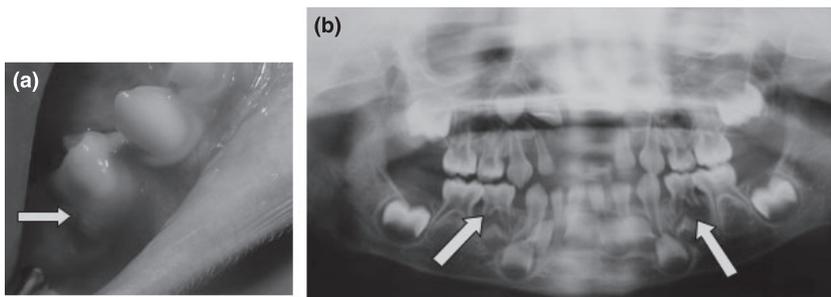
Clinical view (a) and orthopantomogram radiograph (b) from patient 1. (a) The white arrow indicates the presence of a recurrent abscess on a left deciduous molar (74). (b) Bone resorption is observed around or beneath the roots of the deciduous molars (74, 84 – see white arrow). All molars show prominent pulp horns extending up to the dentino-enamel junction
